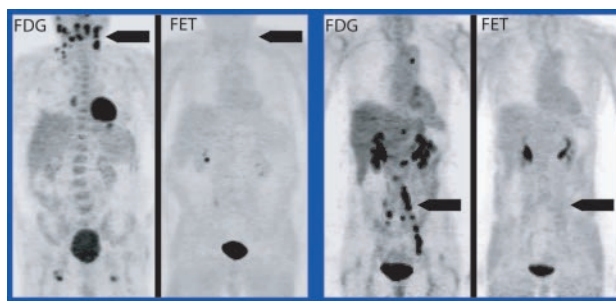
Comparison of ^{18}F -FDG and ^{18}F -FET imaging in patients with (left) non-Hodgkin's lymphoma and (right) ovarian cancer.
